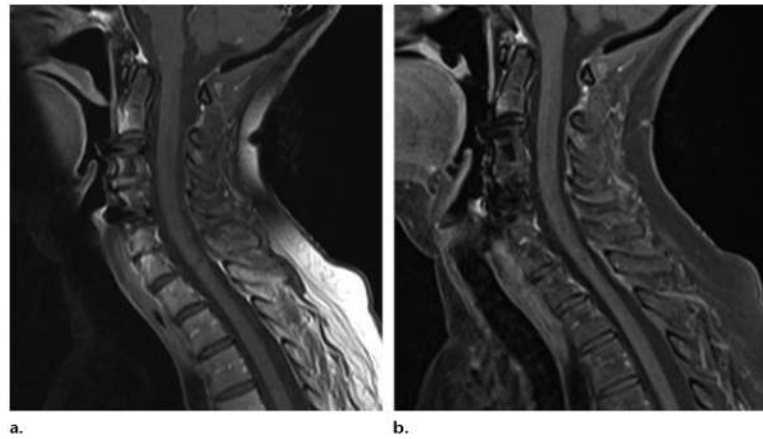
(a) Sagittal T1-weighted MR image with chemical fat saturation (TR, 500 msec; TE, 10 msec) shows heterogeneous fat saturation of the subcutaneous fat in the posterior side of the neck. (b) Dixon (Siemens, Erlangen, Germany) MR image (TR, 610 msec; TE, 12 msec) of the cervical spine shows robust fat suppression. (Images courtesy of Rory Johnson and Peter Cazares.)
